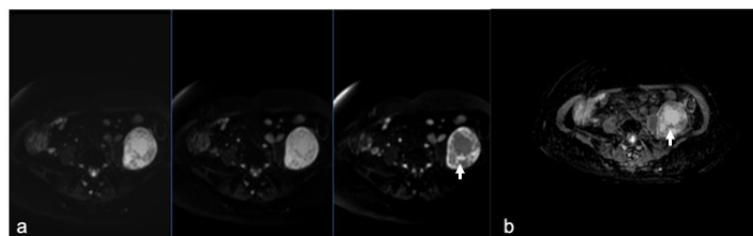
DWI images (b0,400,800) (a) and corresponding ADC map (b) show restricted diffusion at the periphery and along the septa (arrows).
